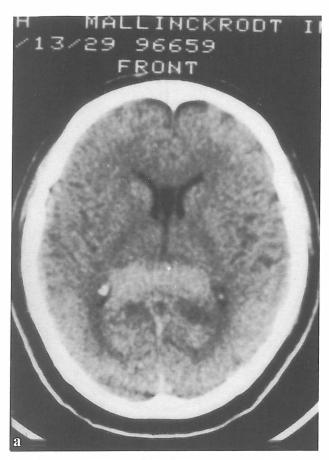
(a-b): Primary CNS lymphoma; axial (a) and (b) post contrast CT of brain shows an isodense periventicular mass with marked enhancement post-contrast injection.
